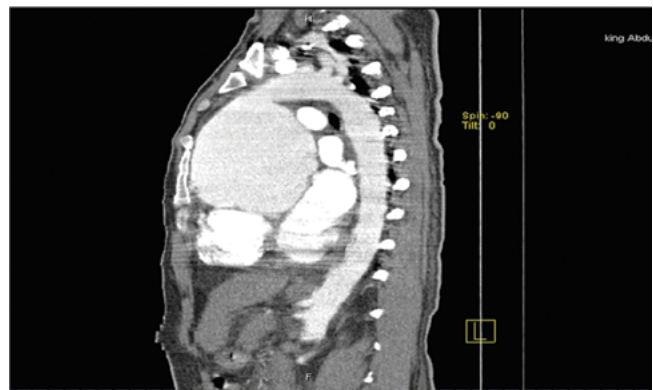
Preoperative computed tomography image showing a 13-cm ascending aortic aneurysm involving the sinuses of Valsalva.
